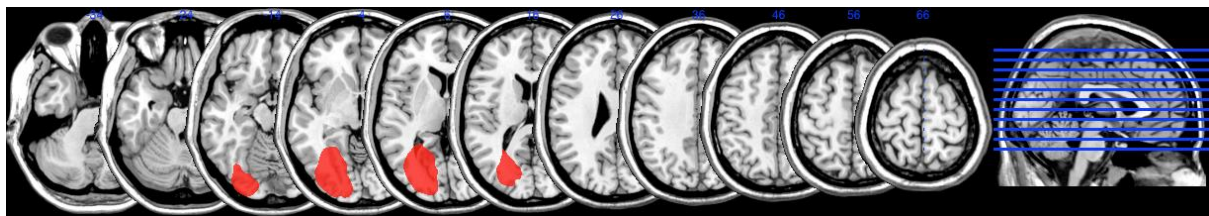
MRI scan of patient KW
